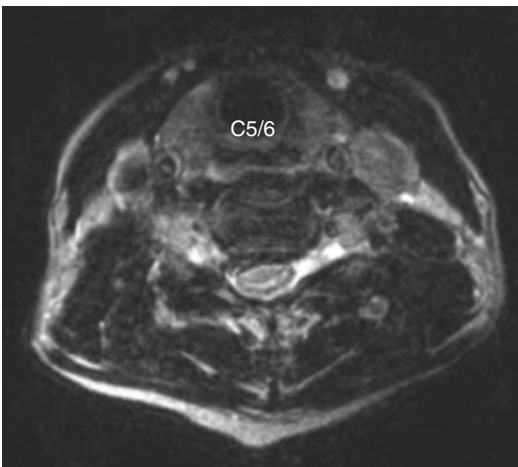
The MRI scan of the cervical spine in axial cuts shows the broad based herniated disc reaching the foramen on the right side
